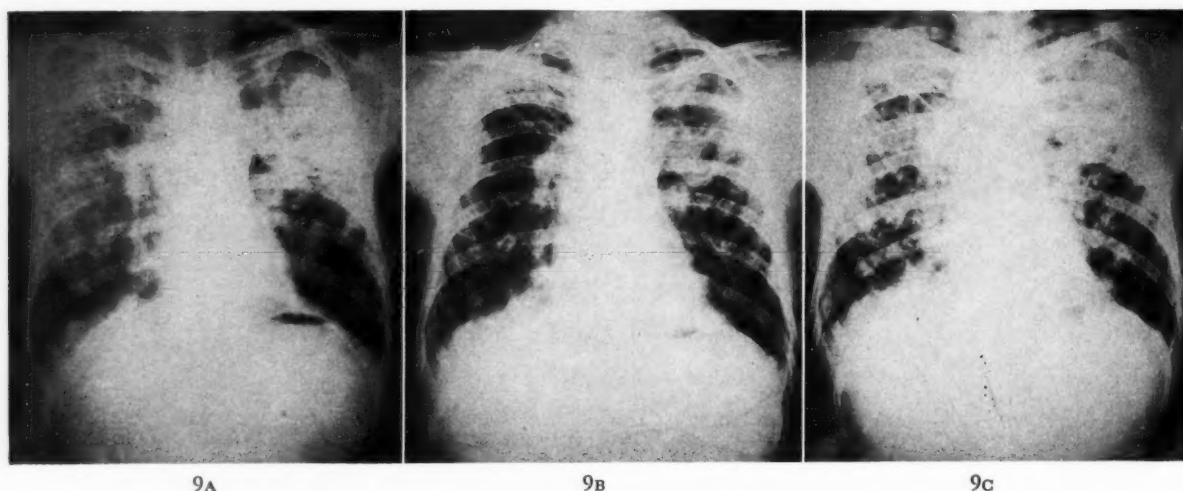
A, B. W. (Case II), appearance of the chest x-ray before ACTH administration. B, clearing of lung fields and decrease in the size of nodules on the ninth day of the second course of ACTH (forty-eighth day of study). C, return of pulmonary densities twenty-five days after completion of the second course of ACTH.
